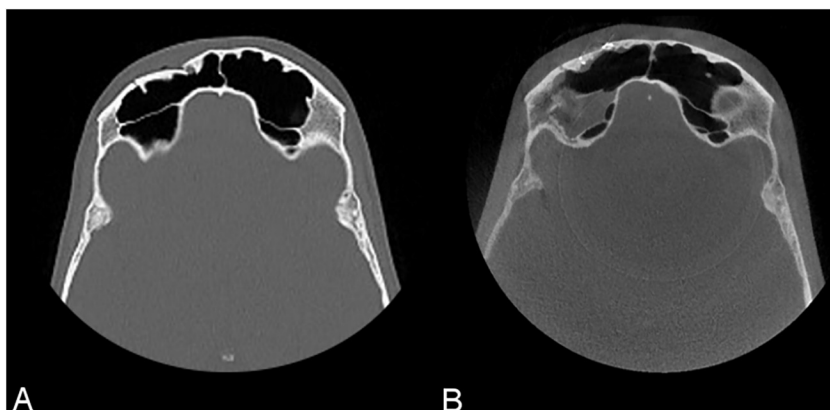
Radiographic evaluation. A. Preoperative CT scan in axial section showing a displaced fracture of the anterior wall of the right frontal sinus. B. Postoperative CBCT in axial section showing a good reduction of the anterior wall.
